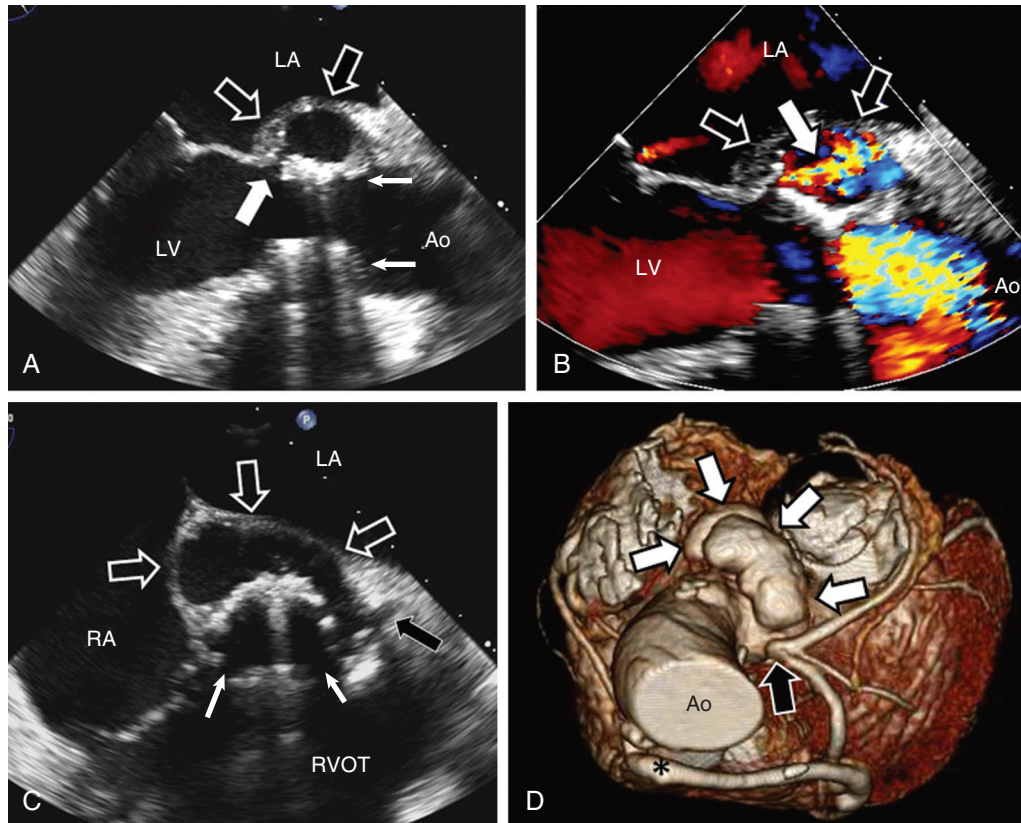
Perianular extension of infection complicating mechanical aortic prosthetic valve endocarditis. A, TEE image shows a large mycotic false aneurysm (open arrows) within the mitral-aortic intervalvular fibrosa adjacent to the prosthesis (small arrows). Communication with the LV outflow tract is evident (large white arrow). B, Color Doppler image demonstrates flow communication (arrow) into the mycotic false aneurysm (open arrows) during systole, at which time the larger color flow signal exits the aortic prosthesis into the ascending aorta (Ao). C, Short-axis TEE imaging of the mechanical aortic prosthesis (small arrows) indicates that the large mycotic false aneurysm (large open arrows) extends posteriorly adjacent to the left atrium (LA), bulges toward the right atrium (RA), and extends to the left main coronary artery (black arrow). D, Computed tomography with three-dimensional reconstruction, viewed from above and tilted anteriorly to show the posterior aortic root, shows the large posterolateral mycotic false aneurysm (white arrows) extending from the aortic root and encroaching upon the left main coronary artery (black arrow). A saphenous vein bypass graft (*) to the left anterior descending coronary artery also is seen. RVOT = right ventricular outflow tract.
